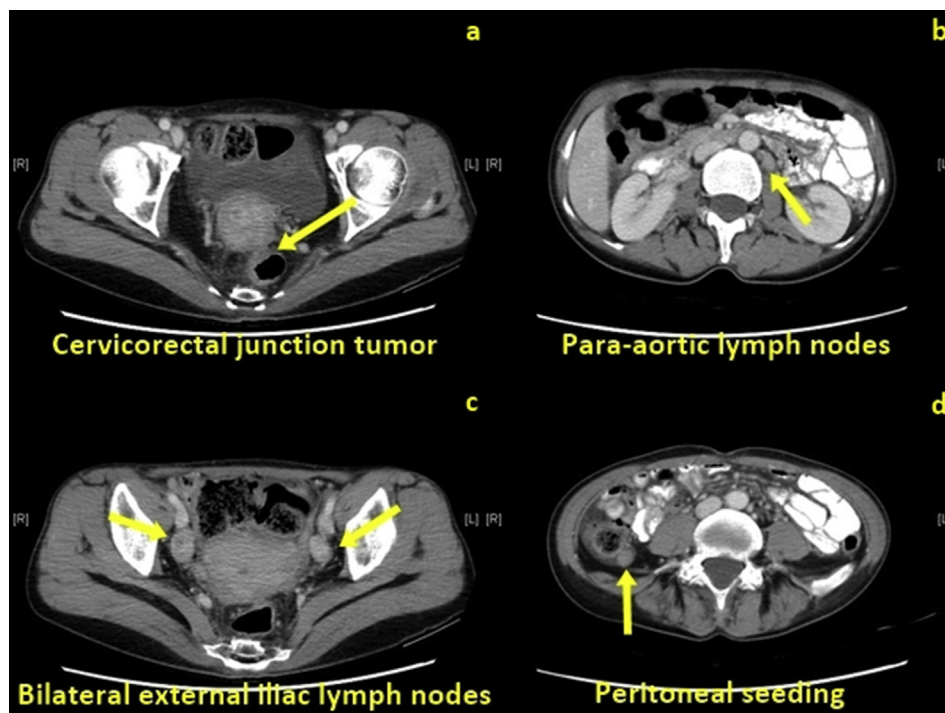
Abdominal computed tomography revealed a suspicious malignant lesion at the cervicorectal junction (a), para-aortic lymph nodes (b), bilateral external iliac lymph nodes (c), and peritoneal seeding (d).
